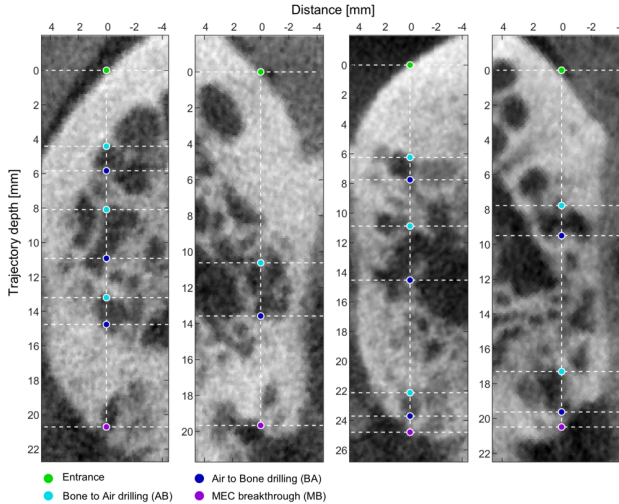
Pre-operative CT image of four subjects showing the planned trajectory for middle ear access with the corresponding transitions depths determined by the refinement algorithm.
